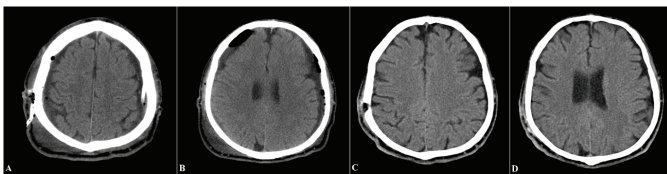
A, B. Early postoperative computed tomography (CT) images reveal air intensities in the subdural space with an indwelling drain. C, D. CT images one month after operation reveal complete improvement in the subdural hemorrhage
